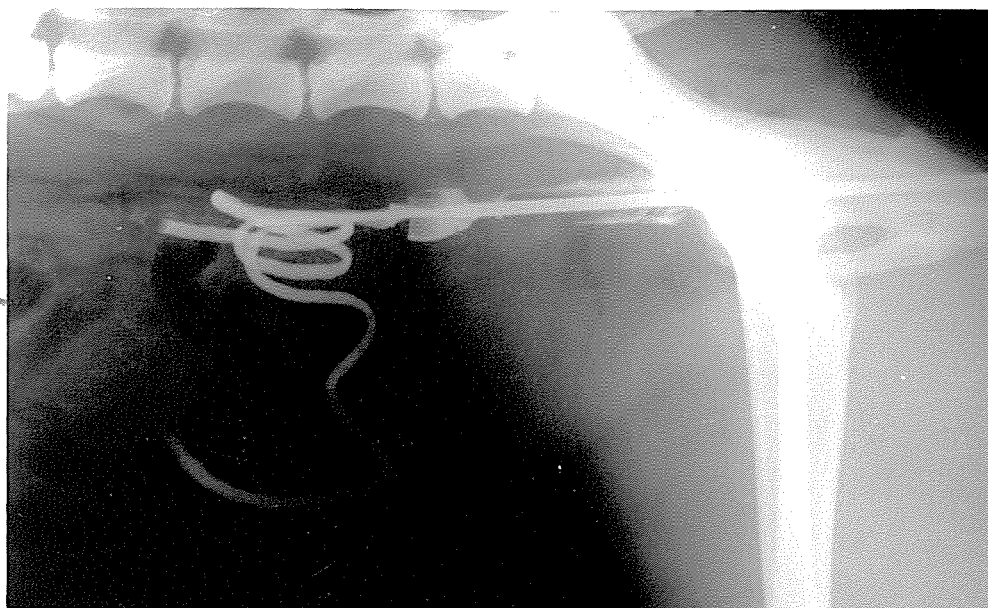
Radiographs demonstrating the site of insemination using the “Norwegian” technique.
